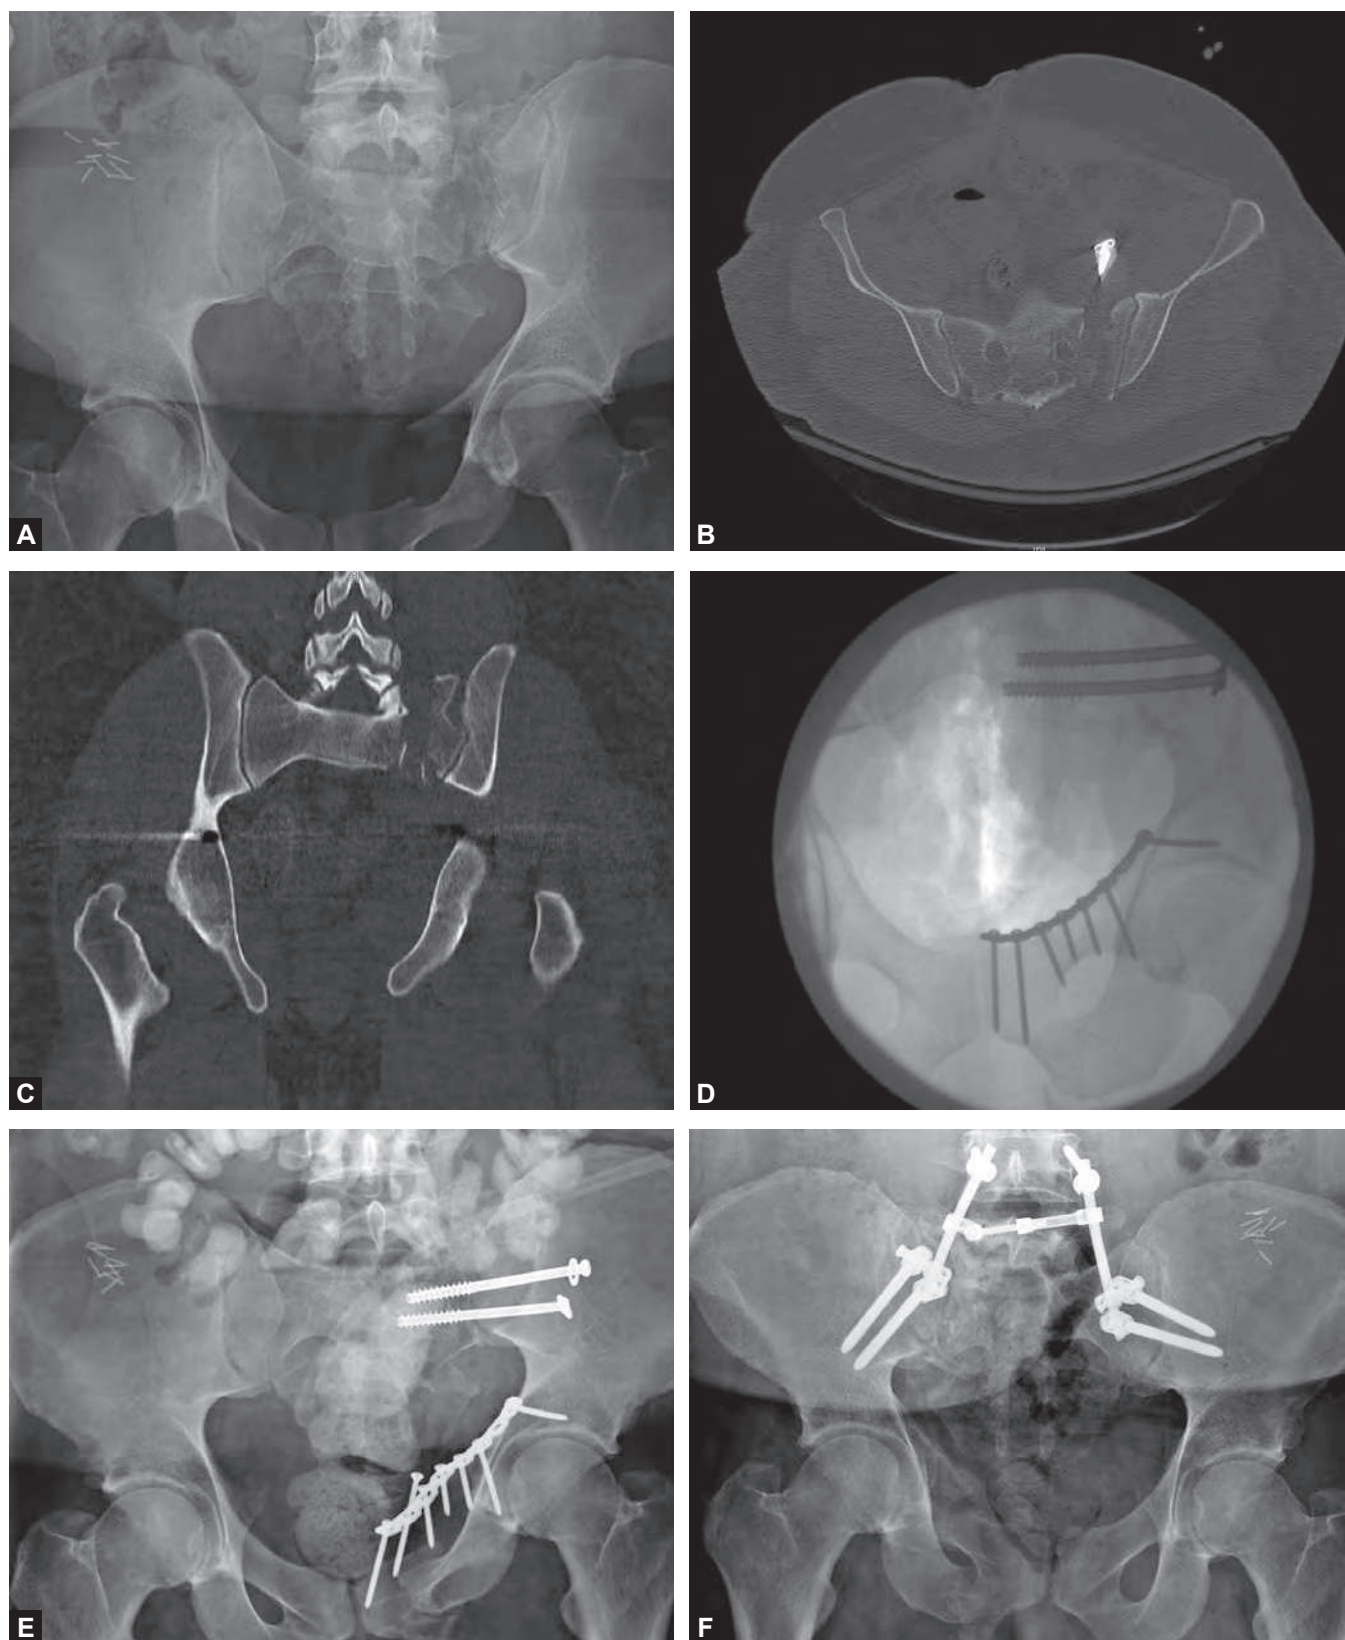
to F: Initial trauma bay anteroposterior (AP) pelvis radiograph (A) demonstrating the H-type sacral fracture and right anterior pelvic ring fracture. Coronal (B) and axial (C) pelvic computed tomography images demonstrate the severe comminuted, unstable sacral fracture with three-dimensional coronal reconstruction (D). Postoperative AP pelvis (E) and lateral lumbosacral spine radiographs (F) demonstrate L4-S1 spinopelvic instrumentation (Synthes Pangea, West Chester, PA), right iliosacral screw fixation with a Synthes partially threaded 6.5 mm cannulated screw, and open reduction internal fixation (ORIF) R anterior pelvic ring fracture with a Synthes 3.5 mm pelvic reconstruction plate.
